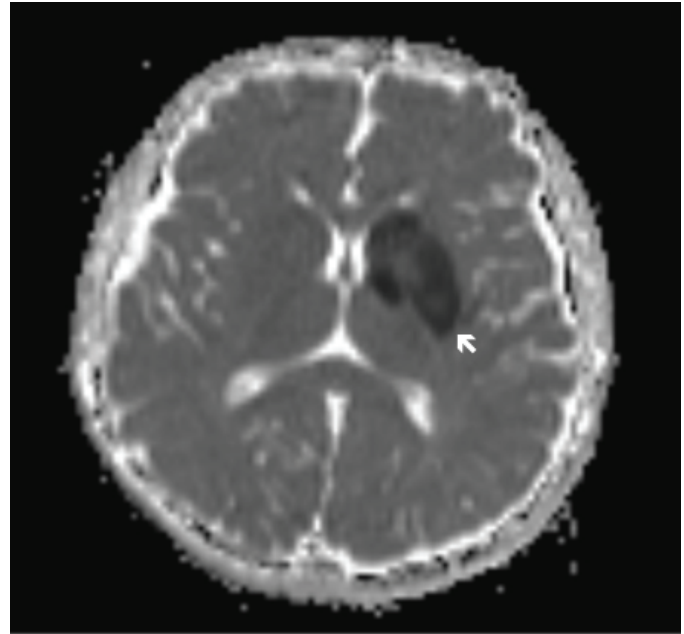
Diffusion MRI showing diffusion restriction, consistent with the ischemic area in the left lentiform nucleus
